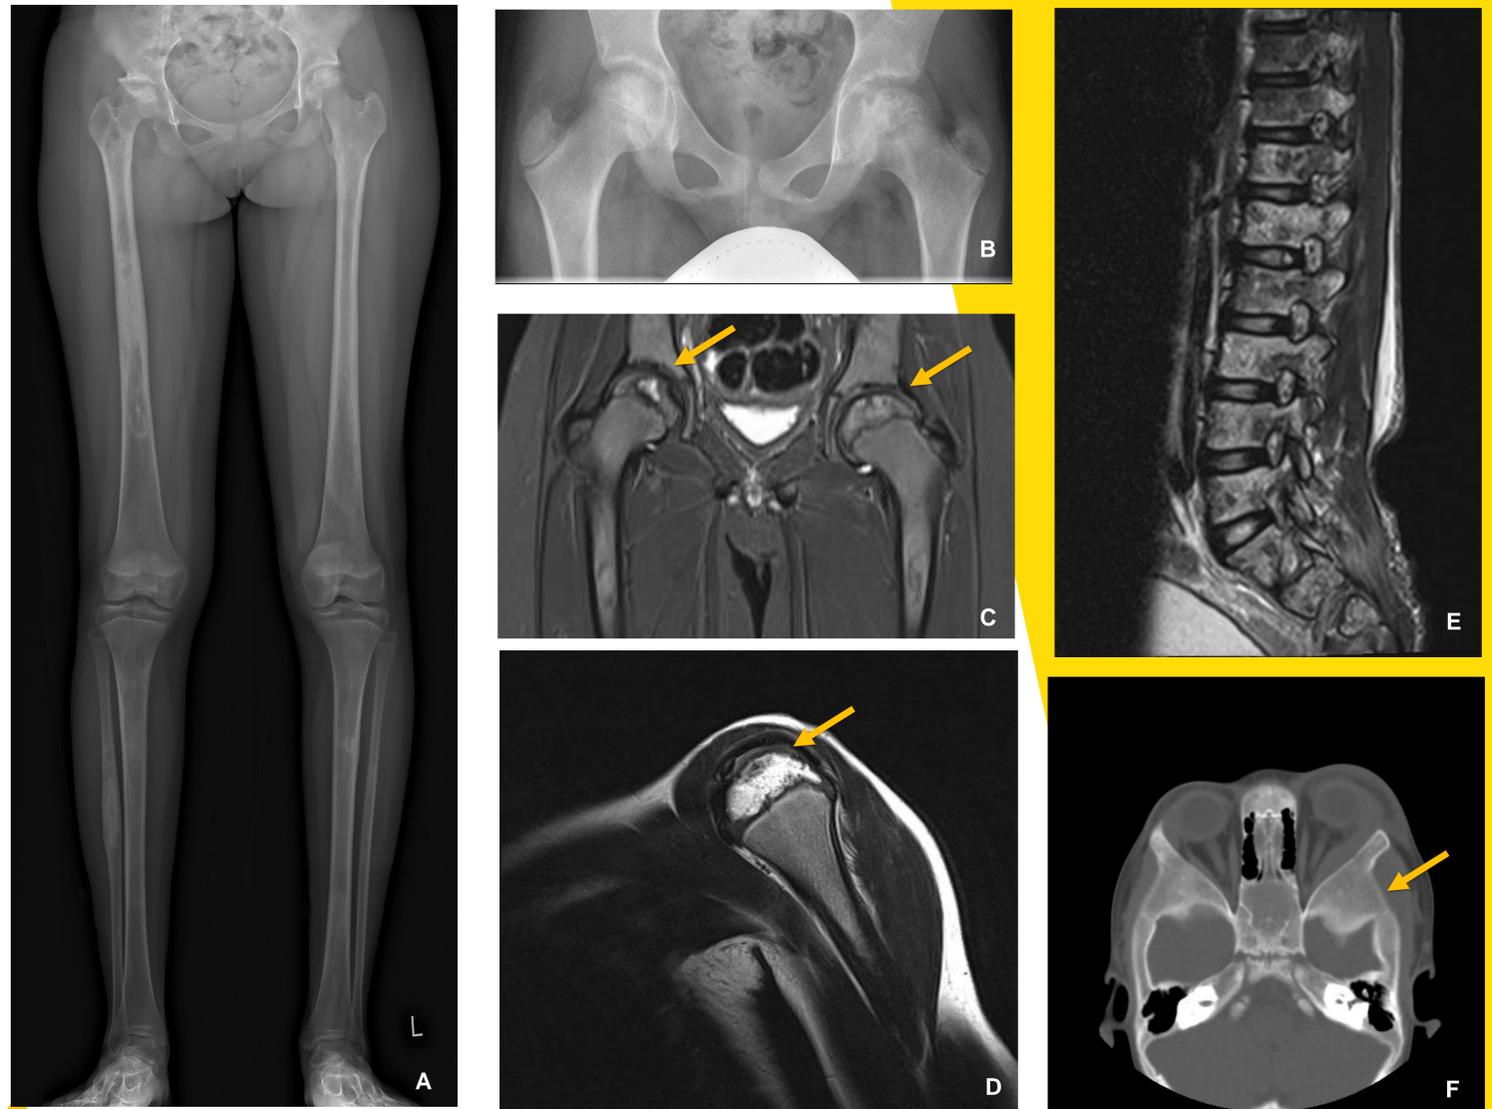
Diversity of Bone Disease in SCD. A) Patient with bilateral femoral head AVN and femur/tibial sclerosis due to bony infarcts. B) Possible bilateral femoral head AVN on Xray. C) MRI showing increased STIR intensity in femoral heads of the patient in (B), confirming bilateral AVN. D) Humeral head AVN. E) Bone infarcts throughout the thoracic, lumbar and sacral vertebral bodies. F) Sphenoid bone infarct with orbital hematoma.
